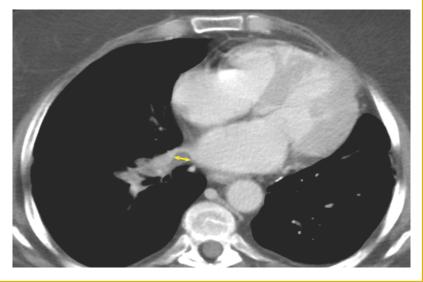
CT Scan After 14 Weeks of Temsirolimus Showing Significant Regression of the Left Atrial Mass.
